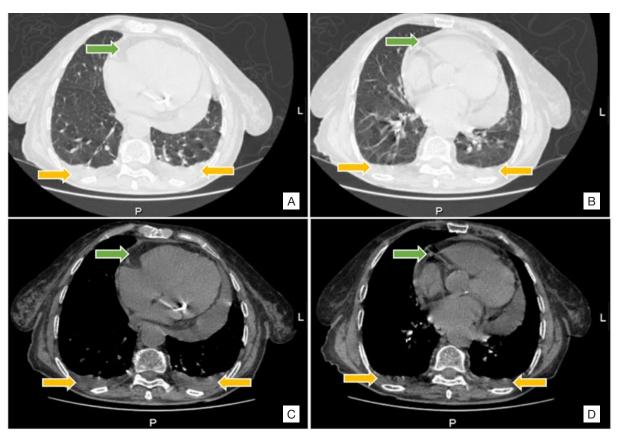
(A) and (B) Computed tomography in two different plans using pulmonary window and showing circumferential pericardial effusion (green arrows) and bilateral pleural effusion (yellow arrows). (C) and (D): same computed tomography now using a mediastinal view reveals the same findings. Pleural effusion is best identified in the pulmonary view; the pericardial effusion, in the mediastinal view (L – Left, P – Posterior).
